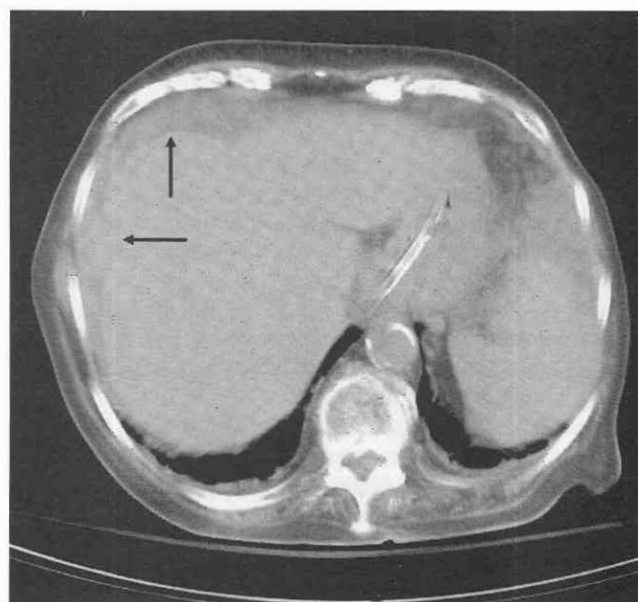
Peritoneal tumor implants are more likely to occur along the undersurface of the diaphragm because of the anatomic structure of the peritoneum. CT scan shows small tumor implants (arrows) on the undersurface of the diaphragm.
